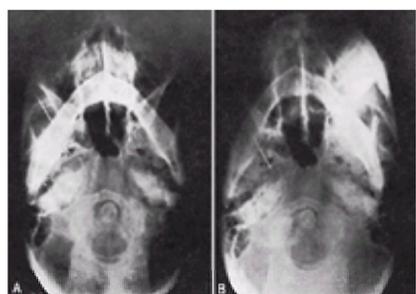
Radiographic visualization of gasserian ganglion block. A: The point of the needle is entering the foramen ovale. B: The needle has passed through the foramen and rests over the trigeminal depression of the petrous portion of the temporal bone. After B was taken, absolute alcohol, in 0.1-mL aliquots, for a total of 0.5 mL, produced analgesia of the second and third divisions.
